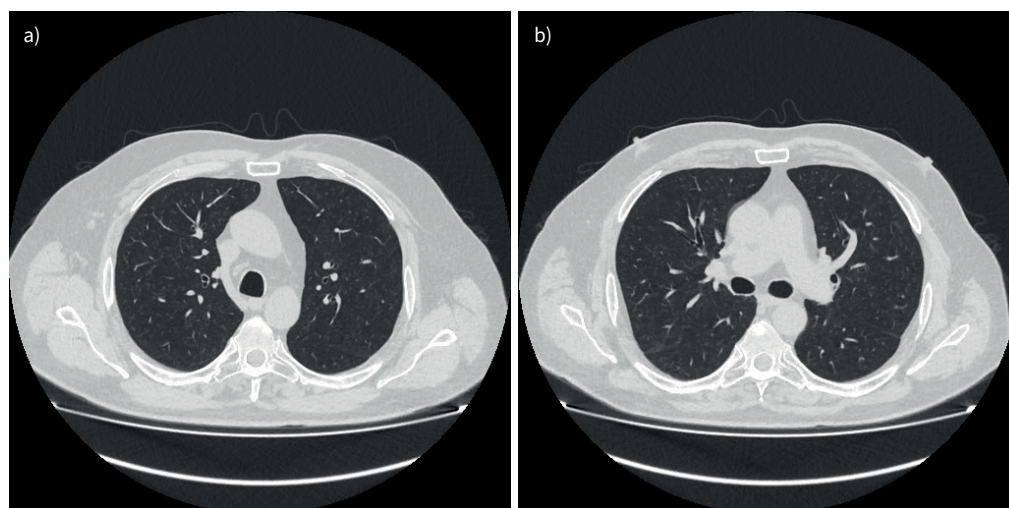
a, b) Follow-up chest computed tomography (after 1.5 months of treatment with corticosteroids and anti-TNF- α discontinuation): resolution of ground-glass opacities and mosaic attenuation.
